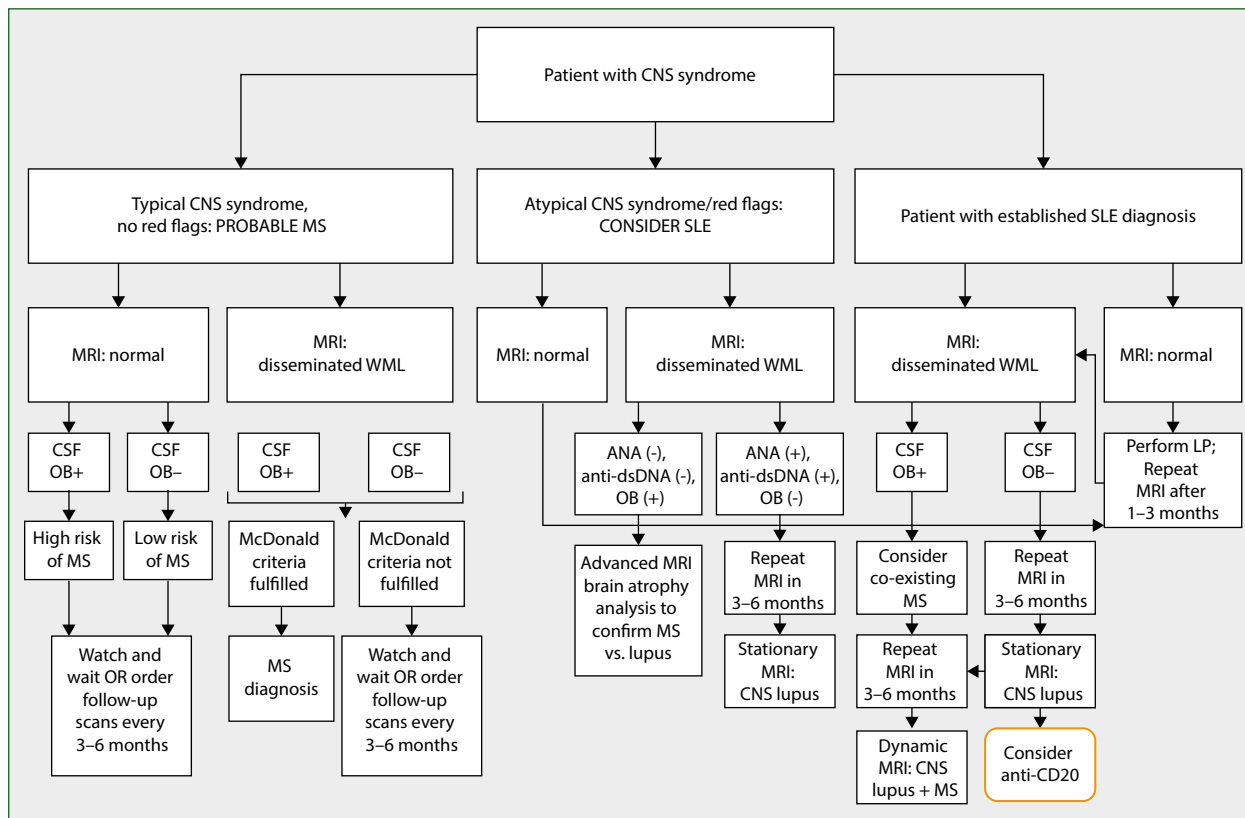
Suggested algorithm for MS vs. NPSLE differentiation. MS – multiple sclerosis; SLE – systemic lupus erythematosus; CNS – central nervous system; MRI – magnetic resonance imaging; OB – oligoclonal bands; WML – white matter lesions; LP – lumbar puncture; ANA – antinuclear antibodies; anti-dsDNA – anti-double stranded DNA antibodies; CSF – cerebrospinal fluid
